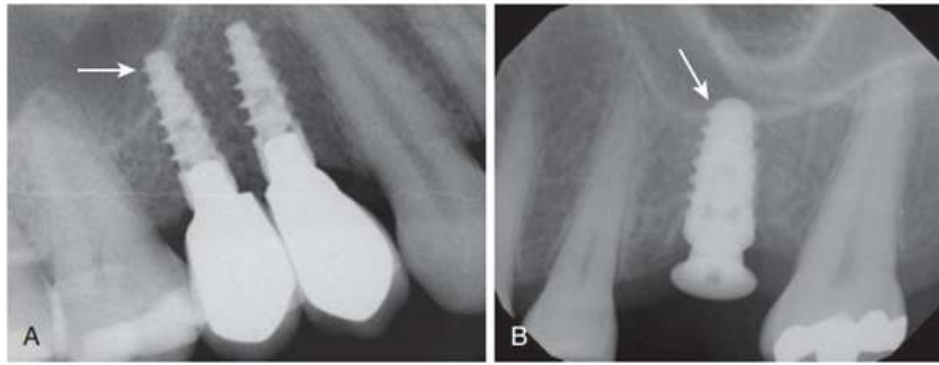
SA-2. (A) Radiograph depicting an SA-2 (maxillary second premolar) and SA-1 (maxillary first molar). (B) SA-2 implant that includes implant insertion with penetration into the maxillary sinus proper 1 to 2 mm without bone grafting.]
